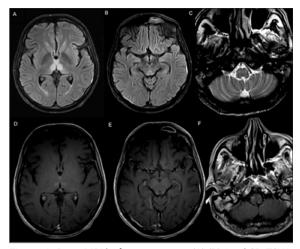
Brain MRI before treatment. (A) (B) Axial 2D T2W FLAIR revealing bilateral hyperintensity of the medial thalamus, extending to the hypothalamus, inferior colliculus and periaqueductal grey matter. (C) Axial 2D T2 TSE showing bilateral pyramidal hyperintensity in the medulla oblongata. (D) (E) and (F) Axial 2D T1 SE revealing tenuous enhancement of the previously mentioned affected areas.
